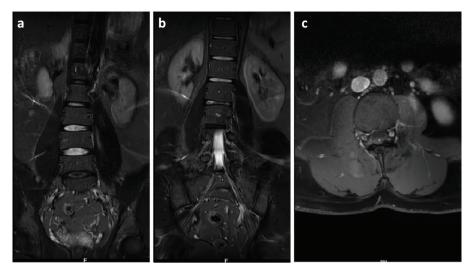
Magnetic resonance imaging of the lumbar spine and pelvis with short TI inversion recovery and contrast. a and b) Coronal image showing contrast enhancement in the left psoas muscle suggestive of an evolving psoas abscess. c) Axial image also showing contrast enhancement in the left psoas muscle.
